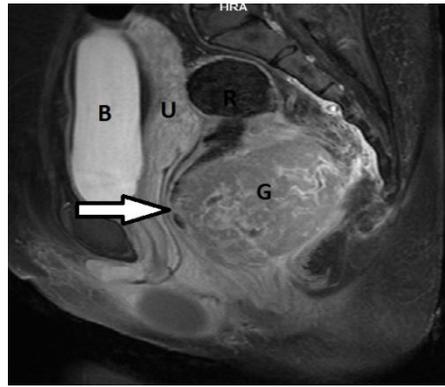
Sagittal T1-weighted MRI Pelvis shows a large lobulated exophytic extraluminal lesion with small intraluminal component with breached mucosa (arrowhead). There is clear plane with the peritoneal reflection, uterus, and sacrum. B, urinary bladder; U, uterus; R, rectal lumen; G, rectal GIST
